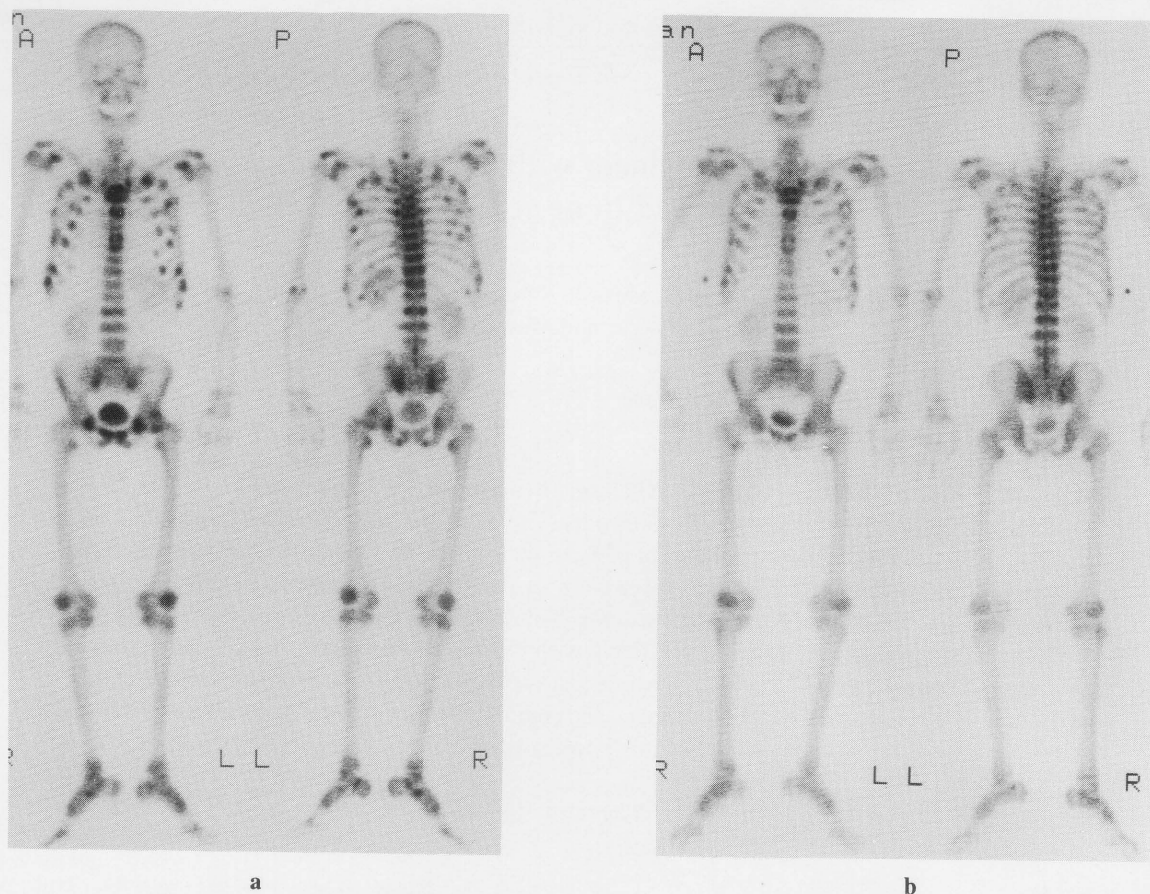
Whole body bone scintigrams (a), before treatment, reveal generally increased uptake of the tracer throughout the skeleton including the periarticular areas, with the kidneys only faintly visualized. There are symmetric focal areas of increased uptake in the pubic rami, ischia and upper femora. In addition, multiple other sites of increased uptake asymmetrically distributed in the ribs, spine and neck of left femur are also present. (b), after treatment with vitamin D, marked improvement is seen.
